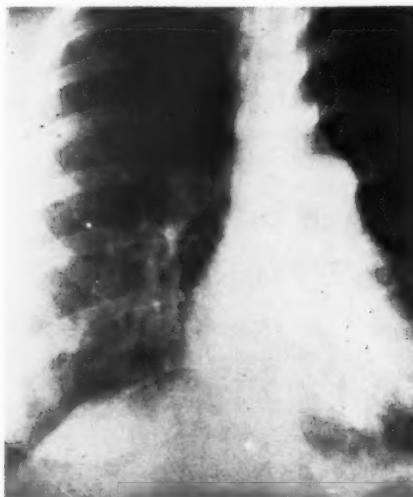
Case I. Postero-anterior roentgenogram of the chest showing vascular channels crossing the lower pole of the right lung root and extending into the region of the right cardiophrenic angle, where they appear to join. The lung roots are not enlarged, but the undivided segment of the pulmonary artery is large.
